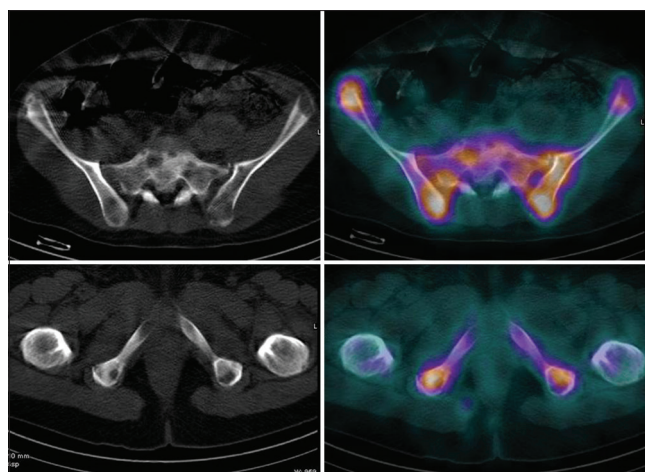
Single-photon emission computed tomography images of pelvis: Increased uptake in multiple pelvic bones with lytic lesions on the corresponding low dose computed tomography images
